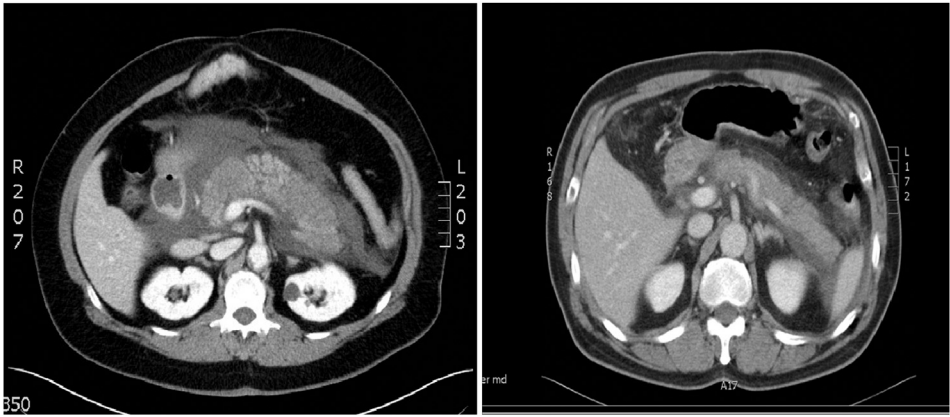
Enhanced CT scan of acute peripancreatic fluid collection.
